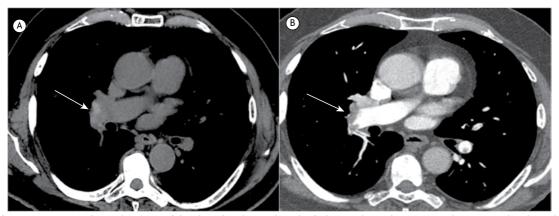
In A, unenhanced CT scan of the chest (mediastinal window) showing hyperdense material present within the right pulmonary artery (arrow). In B, chest CT angiography confirmed the finding to be a thrombus (arrow). Note also a small thrombus in a segmental branch of the left pulmonary artery (in B).
